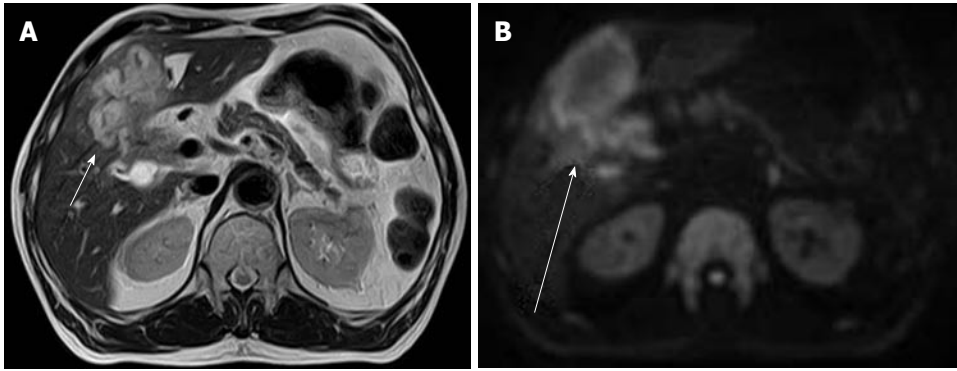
Intrahepatic cholangiocarcinoma in a 70-year-old man. A: Axial T2-weighted image shows high signal intensity liver mass (arrow); B: Diffusion-weighted imaging shows high signal intensity in the lesion (arrow).
